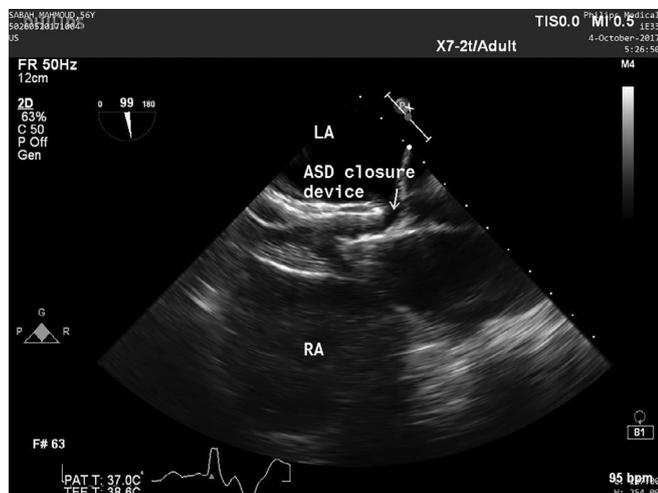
Two-dimensional trans-esophageal echocardiography study: mid-oesophageal bicaval view at 100° angle showing a clear defect between the Amplatzer device and the aorta
